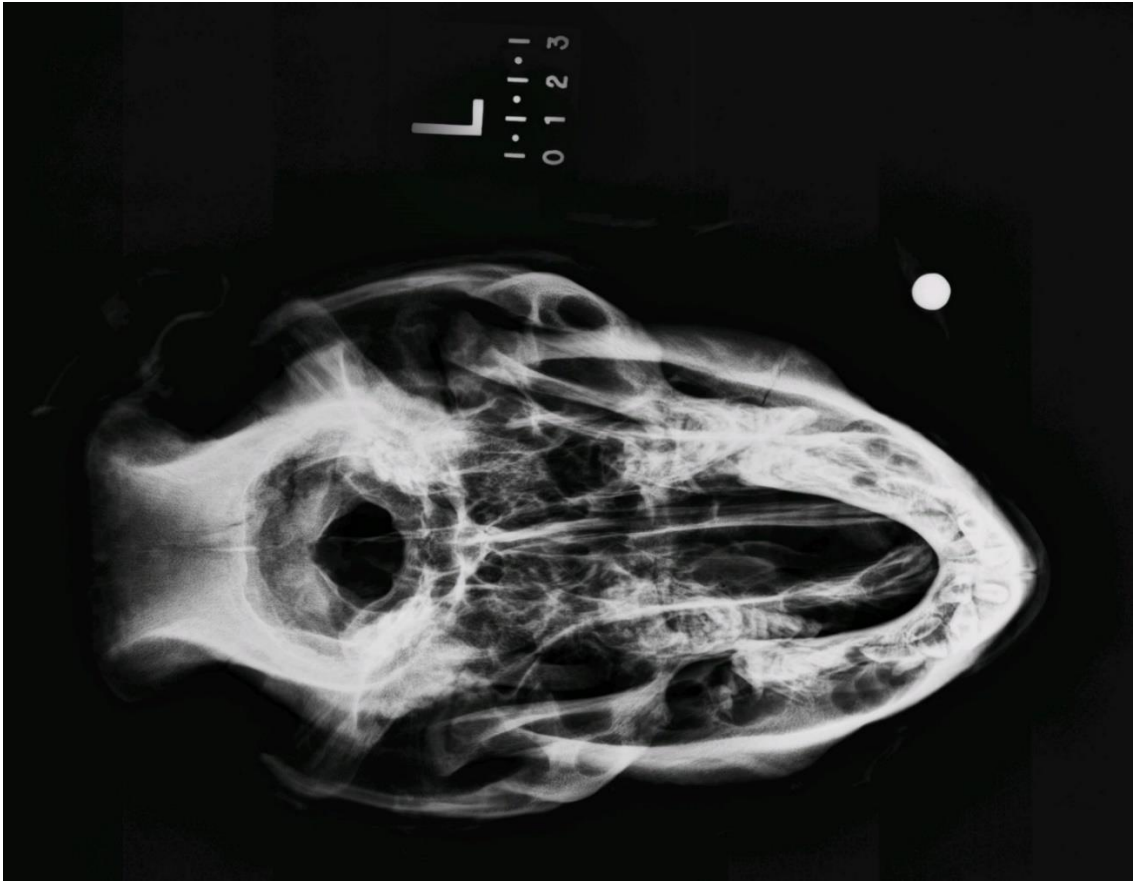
Radiograph of a hog cranium PD with an intact FMJ bullet located in the soft tissue of the ear, rather than embedded in the bone.
